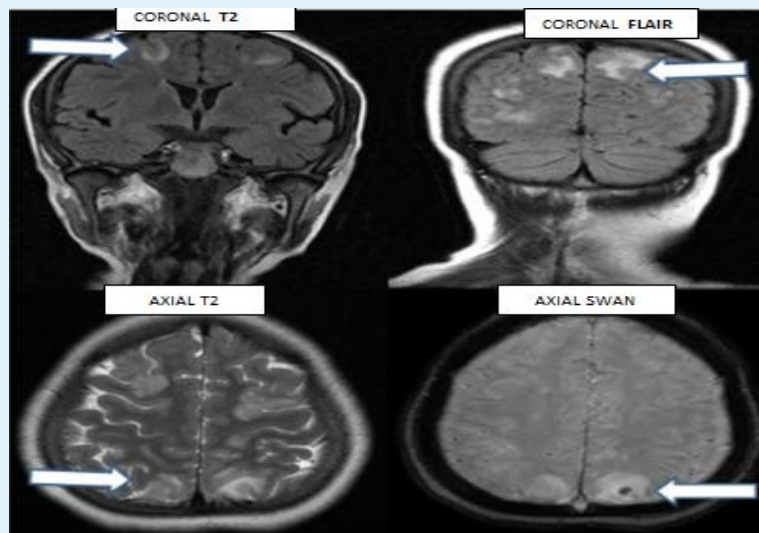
24 year old postpartum women with h/o pre eclampsia, presented with one episode of seizure MRI brain reveals bilateral symmetrical T2/FLAIR hyperintensities involving bilateral frontoparietal region with a foci of hemorrhage in left parietal lobe-Diagnosis of Posterior Reversible Encephalopathy was made.
